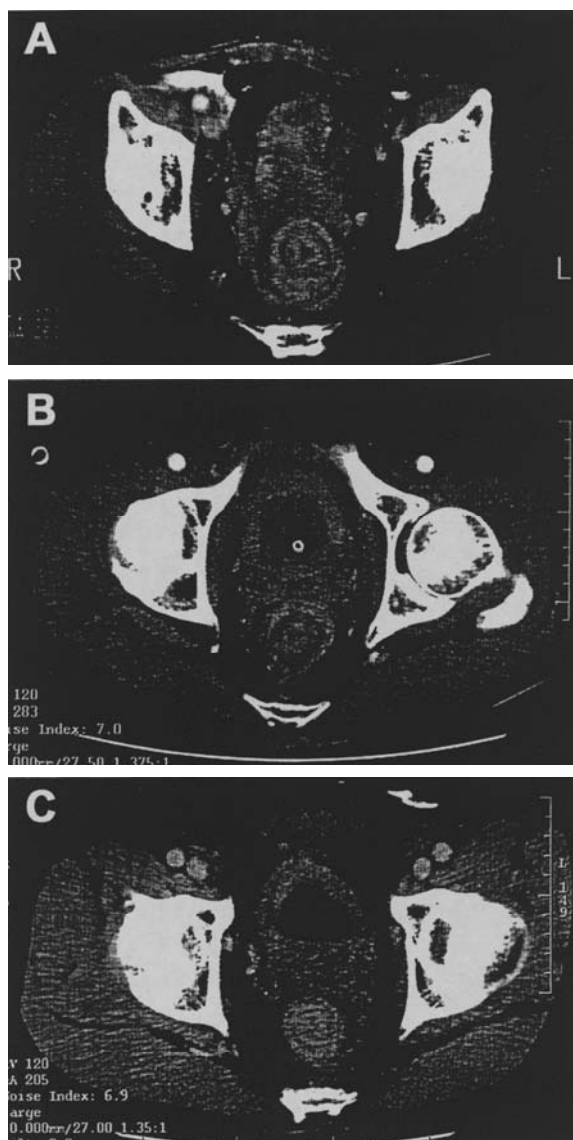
Computed tomography of the pelvis showed an annular-thickened rectal wall. The bilateral lateral ligaments were thickened, but perirectal fatty tissues seemed to be preserved in all three cases.
